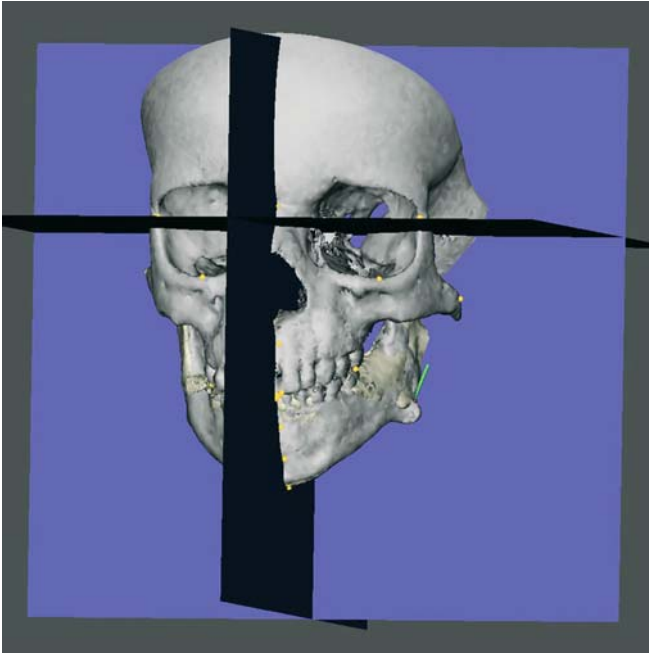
Superimposition of pre-operative and post-distraction 3-D CT hard tissue surface representations using the 3-D cephalometric reference system (3-D CT, patient H.T.)
